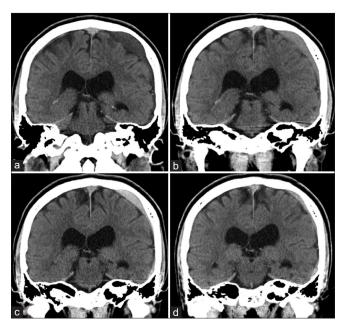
Computed tomograms, showing changes in arachnoid cysts (ACs), the intracystic hemorrhage, and subdural hematoma (SDH) over time (a: 4 weeks, b: 6 weeks, c: 8 weeks, and d: 10 weeks after injury). The intracystic hemorrhage occurred first and the cystic component spread into the subdural space forming an SDH, where it was gradually absorbed while the AC disappeared simultaneously.
